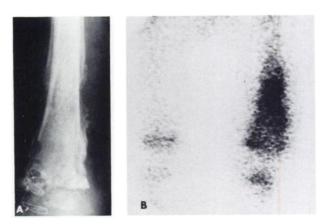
(A) Radiograph of distal left femur 5 weeks after surgery shows active periostitis suggesting involucrum formation, osteoporosis of distal epiphysis, and early fragmentation of distal metaphysis. (B) Bone scan 5 weeks after surgery shows uniformly increased uptake in distal left femur and increased activity in proximal tibial epiphysis.
